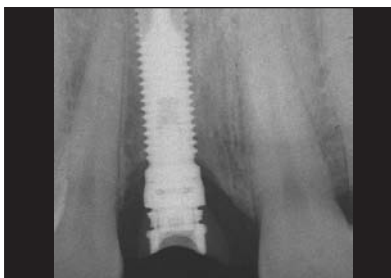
Radiograph at 6 months post-placement of the implant. Normal bone remodeling to the level of the first thread has occurred.
